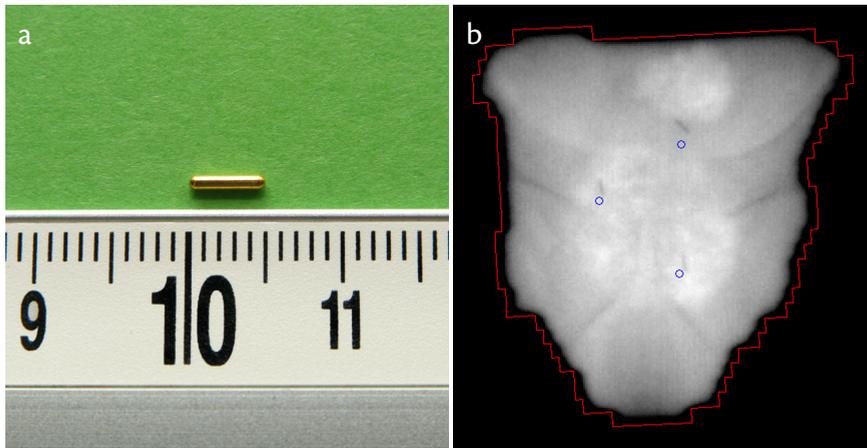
(a) Example of a fiducial gold marker. (b) Electronic portal image taken from the first segment of the irradiation beam. The actual location of the three fiducial markers can be seen as three dark spots and the location of the three markers based on the planning CT-scan are projected by blue circles.
